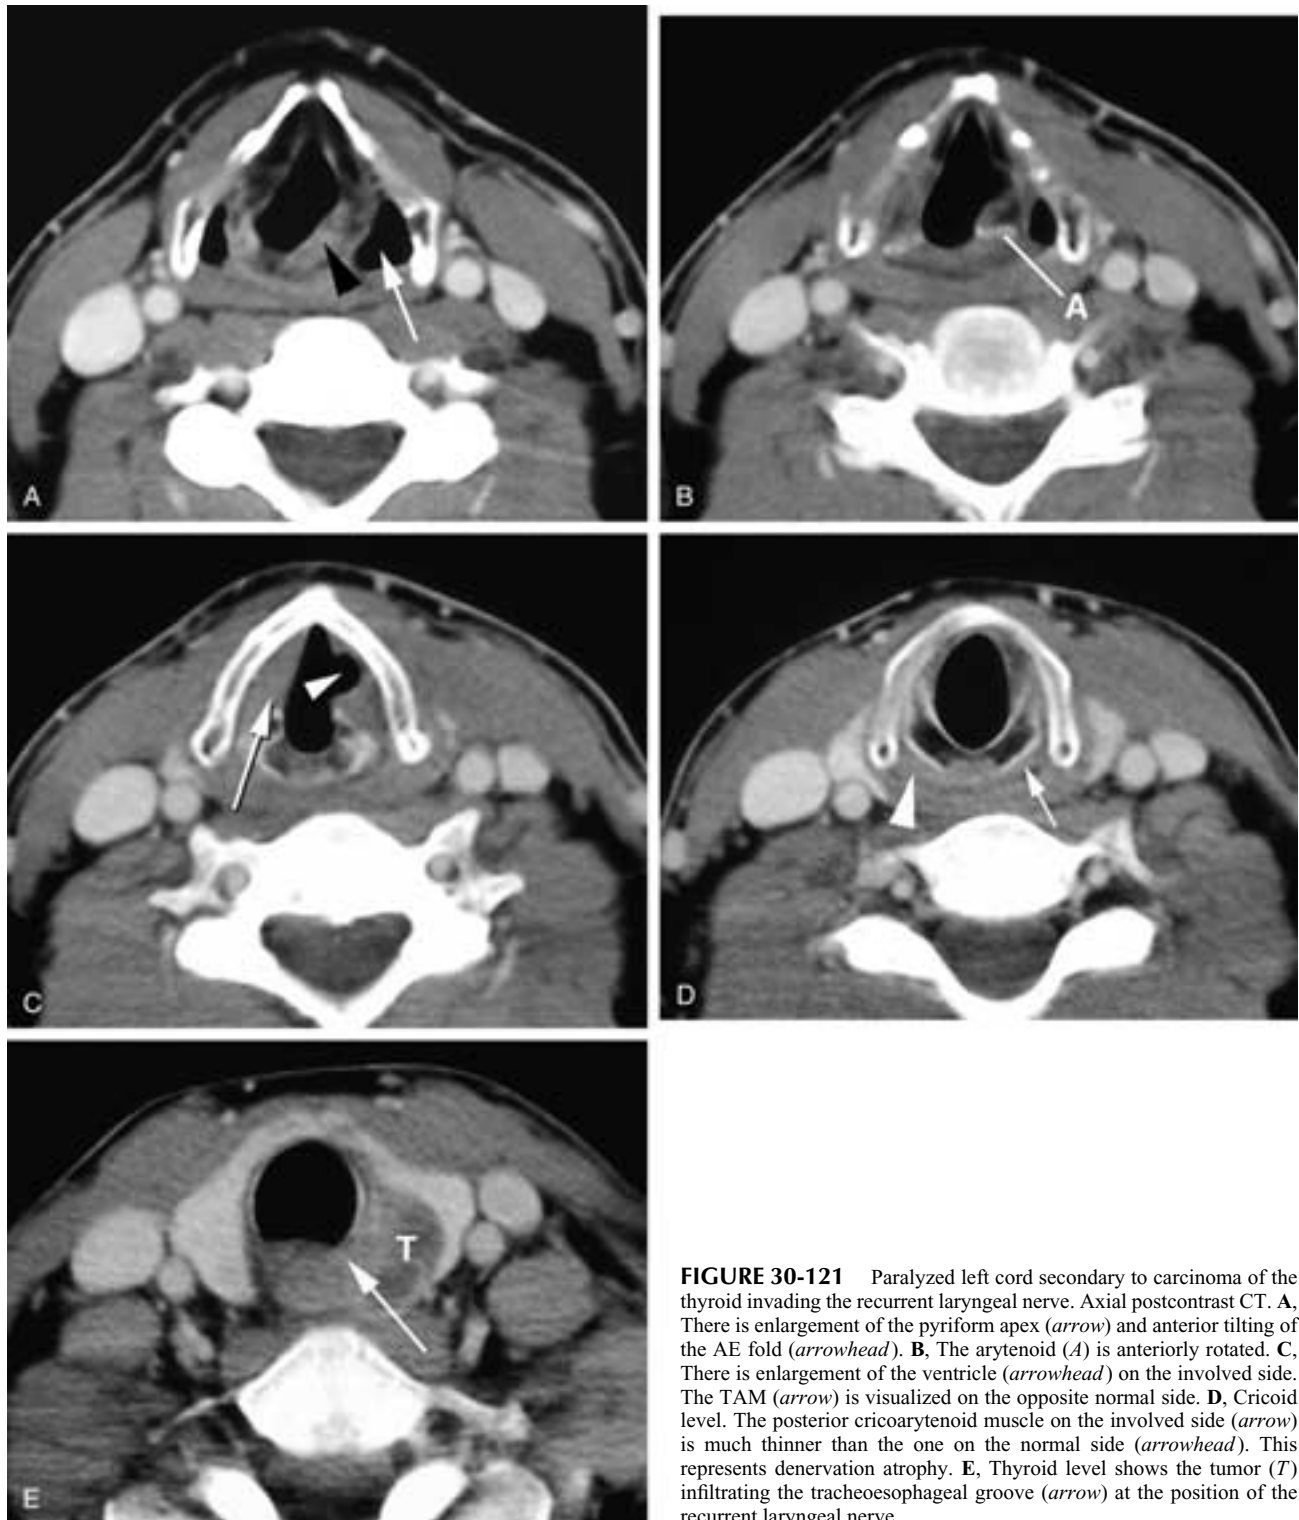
Paralyzed left cord secondary to carcinoma of the thyroid invading the recurrent laryngeal nerve. Axial postcontrast CT. A, There is enlargement of the pyriform apex (*arrow*) and anterior tilting of the AE fold (*arrowhead*). B, The arytenoid (*A*) is anteriorly rotated. C, There is enlargement of the ventricle (*arrowhead*) on the involved side. The TAM (*arrow*) is visualized on the opposite normal side. D, Cricoid level. The posterior cricoarytenoid muscle on the involved side (*arrow*) is much thinner than the one on the normal side (*arrowhead*). This represents denervation atrophy. E, Thyroid level shows the tumor (*T*) infiltrating the tracheoesophageal groove (*arrow*) at the position of the recurrent laryngeal nerve.
